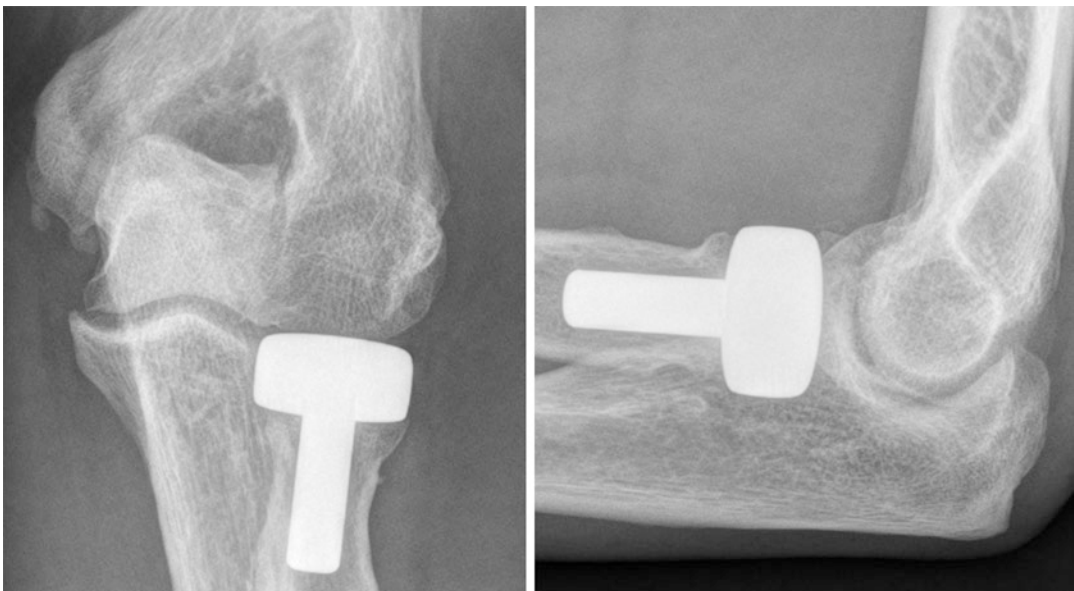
X-ray control anteroposterior and lateral (EVOLVE prosthesis) at 12 years
